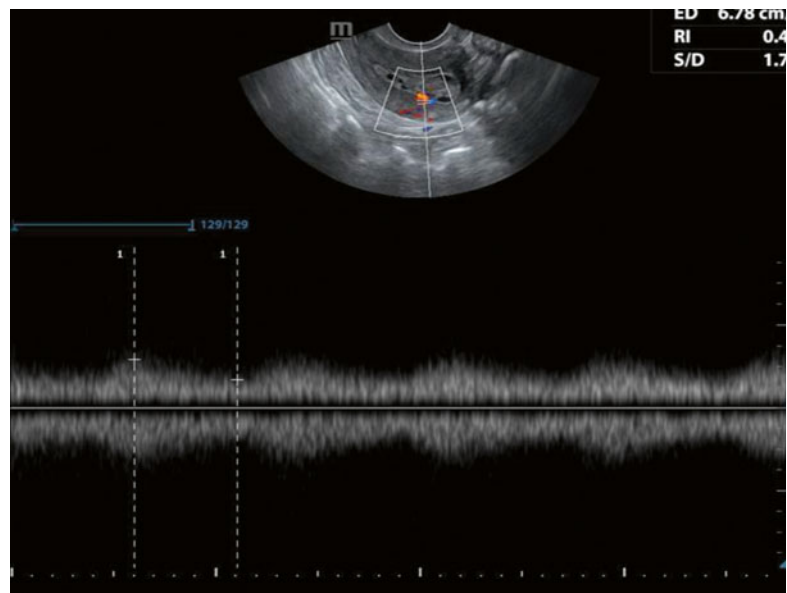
TVS with Doppler showing low-resistance flow pattern in endometrial malignancy
